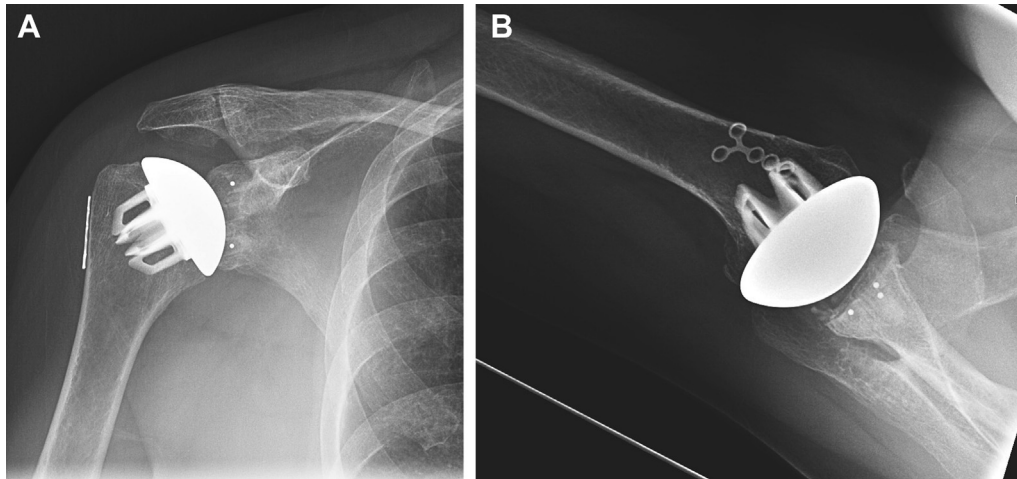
Anteroposterior (A) and axillary (B) radiographs at 2 years' follow-up after Sidus shoulder arthroplasty for symptomatic right glenohumeral joint osteoarthritis.
